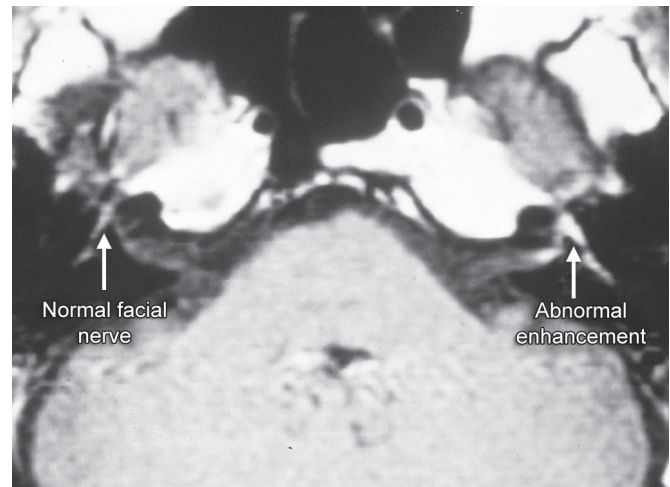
Gadolinium-enhanced magnetic resonance imaging scan of the facial nerve demonstrating enhancement of the left perigeniculate facial nerve extending into the internal auditory canal in Bell's palsy.
